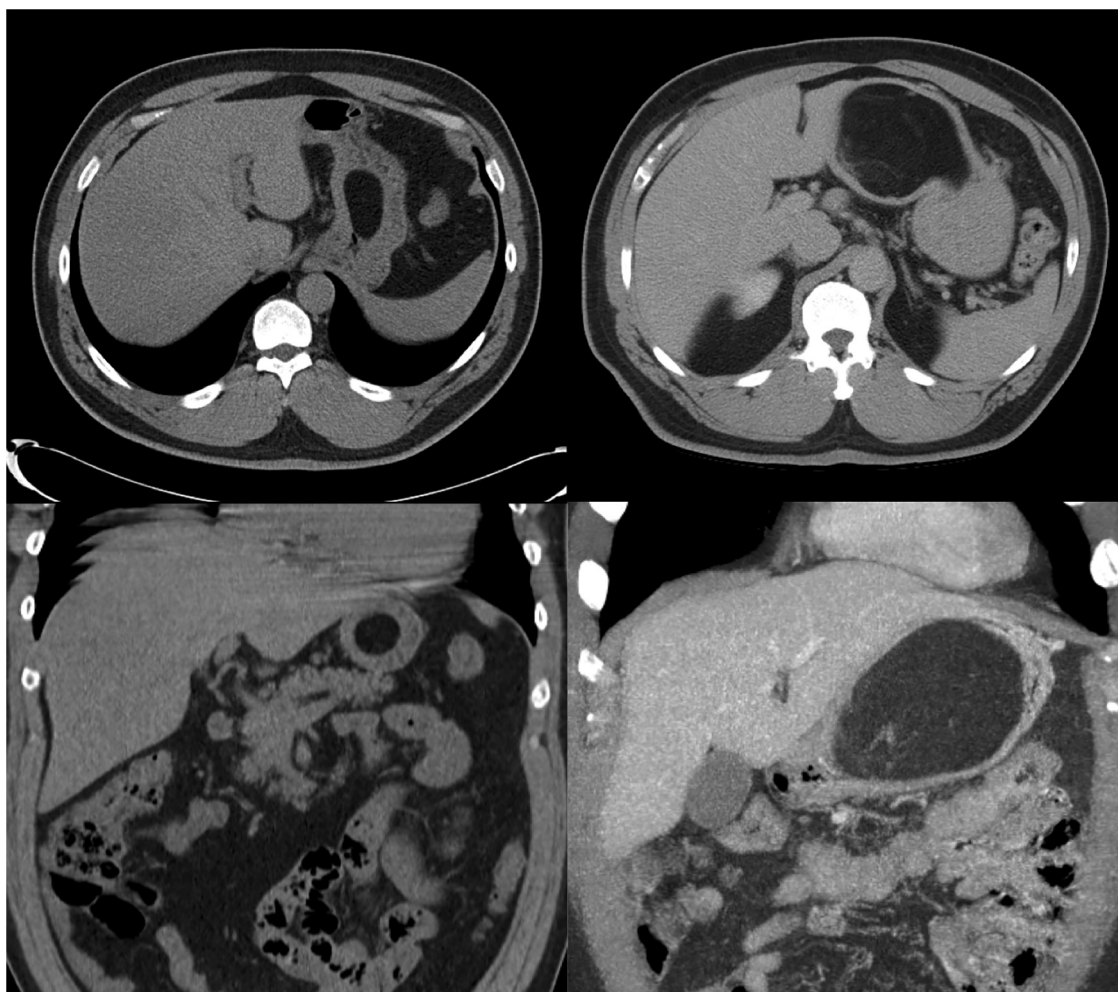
CT images demonstrating interval increase in size from 2010 (Left) to 2017 (Right) of large, low-attenuation gastric mass.
